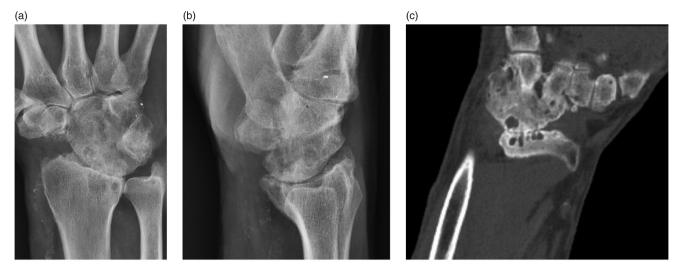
Follow-up 18 years after 4CF. (a,b) Frontal and lateral radiographs reveal arthrosis and DISI malposition. (c) Frontal CT confirms extensive arthrosis.
